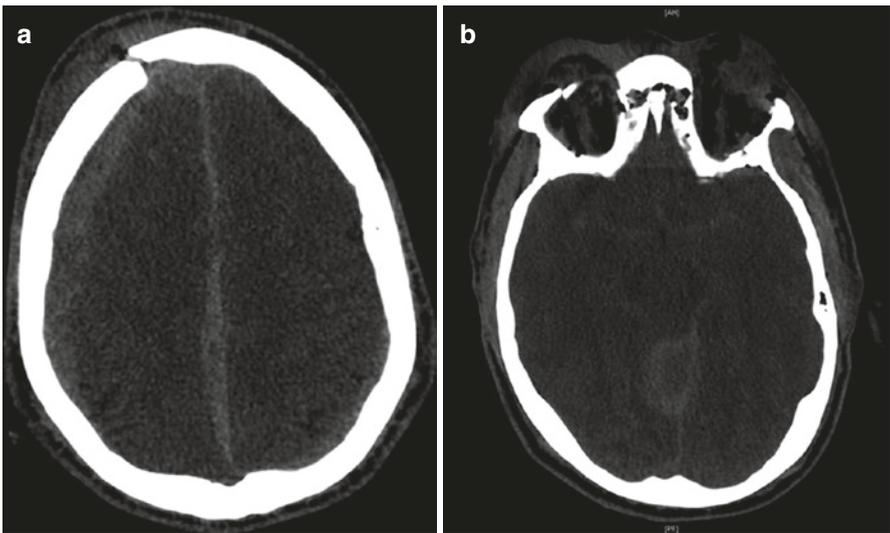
CT head images of a patient following motor vehicle collision
